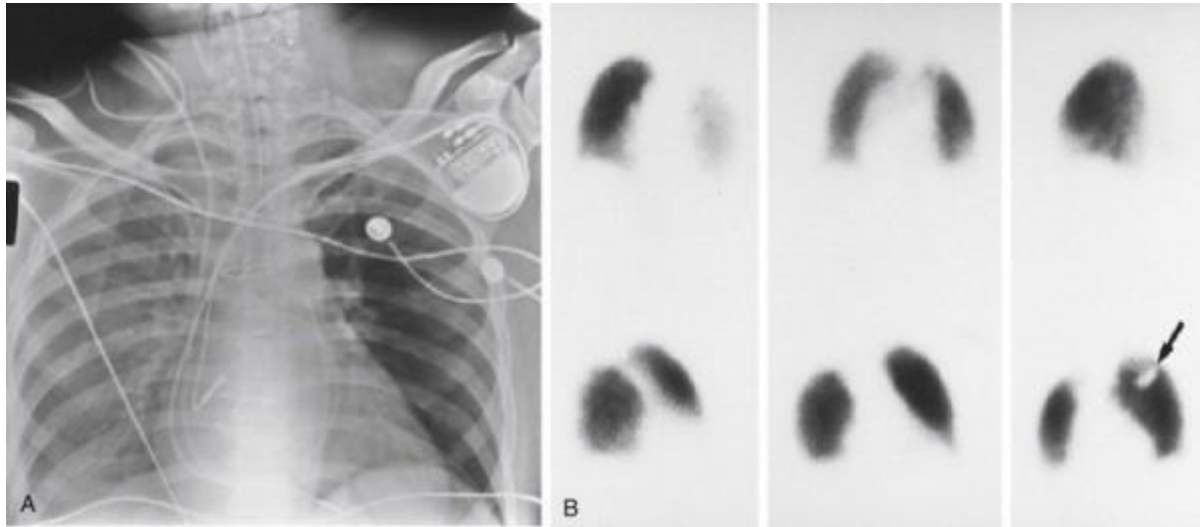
Pleural effusion effect. A, Anteroposterior chest radiograph reveals uniformly greater density in the right lung compared to the left caused by an effusion layering out posteriorly when the patient is supine. B, Corresponding Tc-99m MAA perfusion study shows decreased perfusion to the right lung on the posterior view (upper left-hand image), which is not seen on the other views, tipping off the observer to the explanation for the discrepancy. Blunting of the costophrenic angle is apparent. The pacemaker causes a well-defined defect (arrow).
